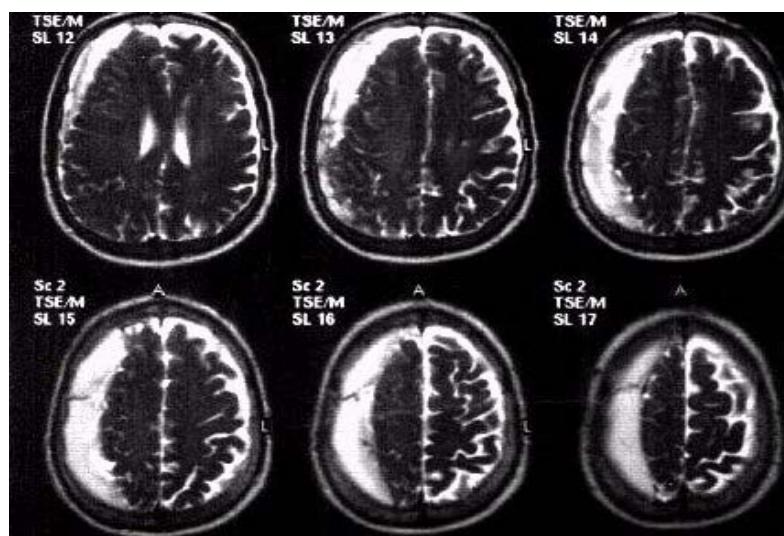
MRI of the brain, showing Rt. CSH with brain atrophy and minimal shift of midline
